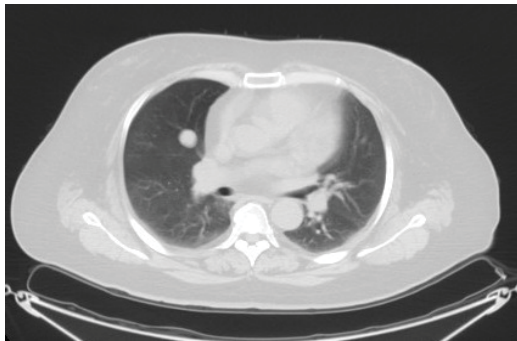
Chest-enhanced CT indicated solid nodules in the middle lobe of right lung, which was 16 × 17 mm in size, of central type, with smooth surface.
